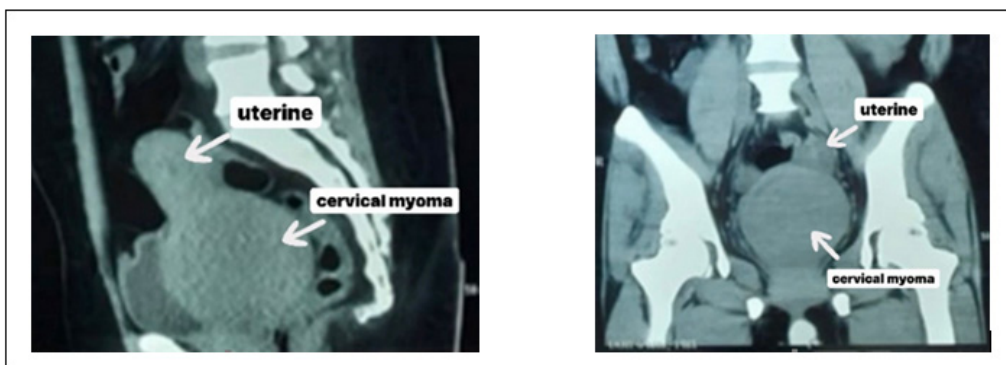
CT Scan examination shows the uterus with cervical leiomyoma
